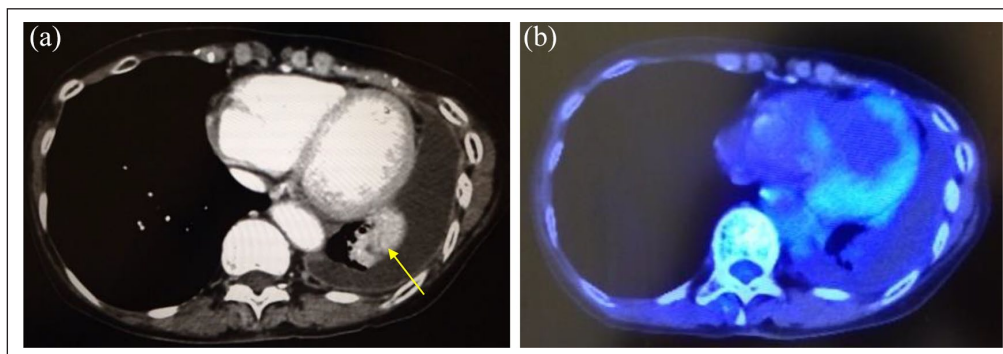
(a) The chest CT shows pleural thickening and a 4 cm mass (arrowhead) in the pleural fluid and (b) The PET scan is negative for FDG accumulation in the mass.
